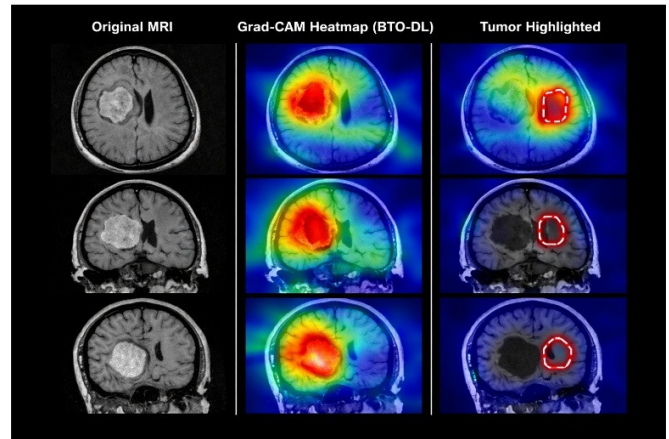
Grad-CAM visualization results for representative MRI samples.
